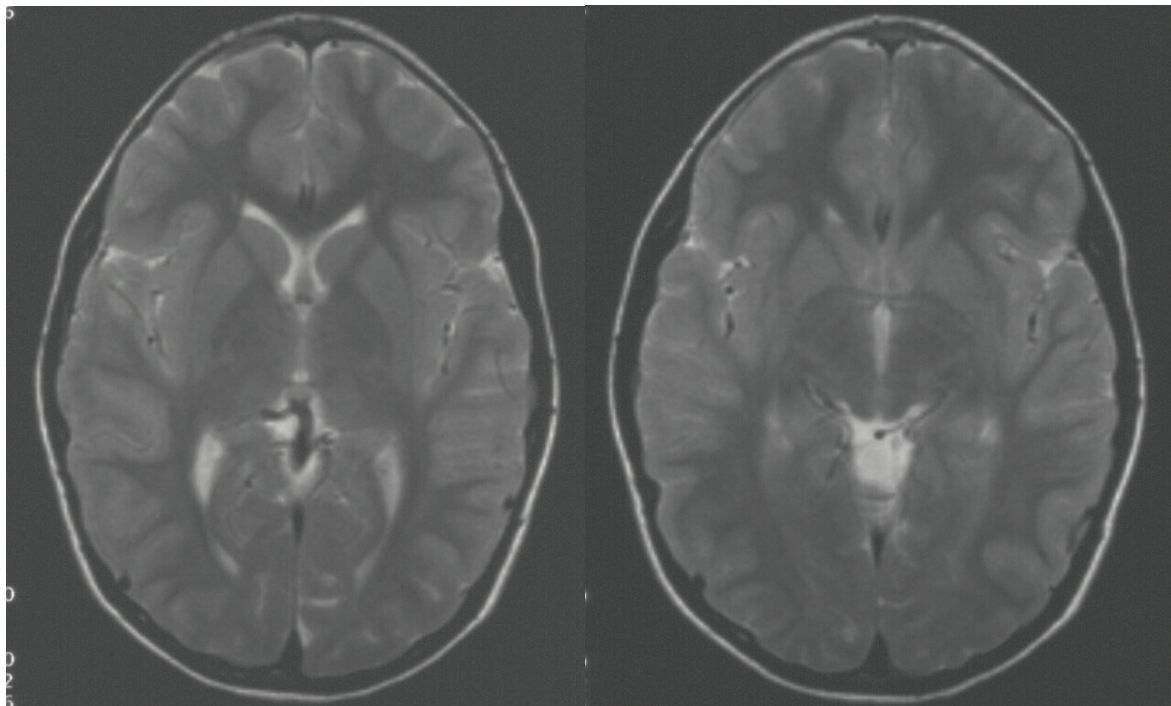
cMRI of proband Y.Z. Note the poor differentiation between cortex and white matter in the occipital region. T2-weighted images.
